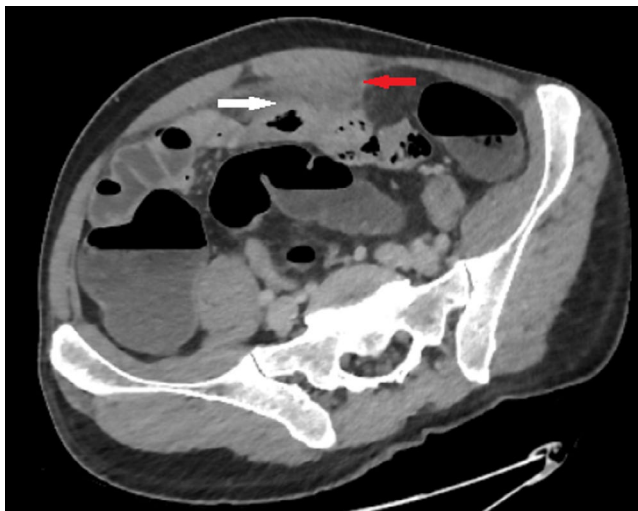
CT scan showing a jejunal diverticulum (white arrow) with surrounding inflammatory changes in the mesenteric fat (red arrow)
